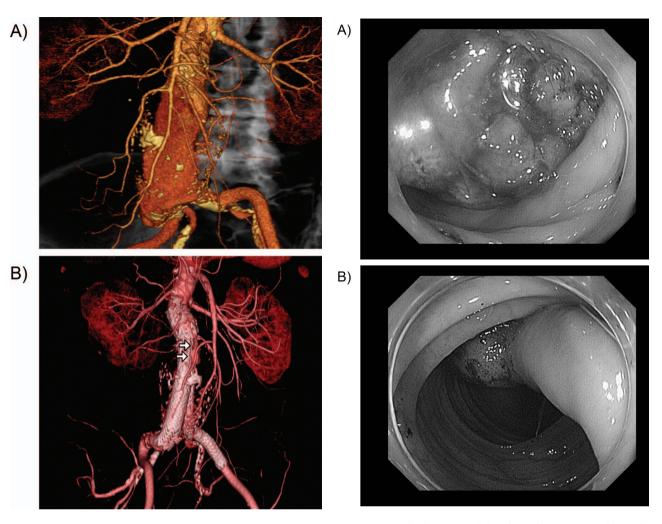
Arterial reconstructions with computed tomography type 2 endoleak from the IMA.
